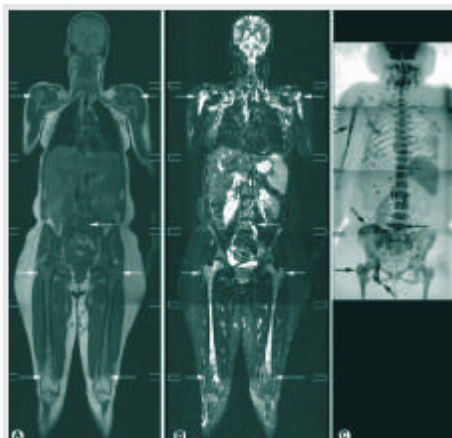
Whole body MRI : A) Coronal T1WI, B) coronal Inversion recovery, C) WB- diffusion
